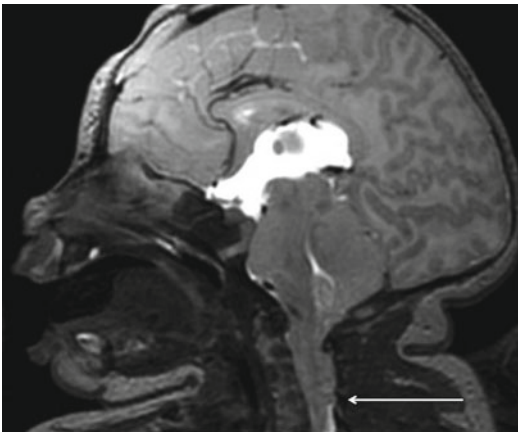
Sagittal T2W MRI image of a neonate with Chiari 2 malformation. The tip of the tonsils (*arrow*) reaches the level of C5 vertebra. Of note the small volume of posterior cranial fossa and the low-lying torcular herophili
